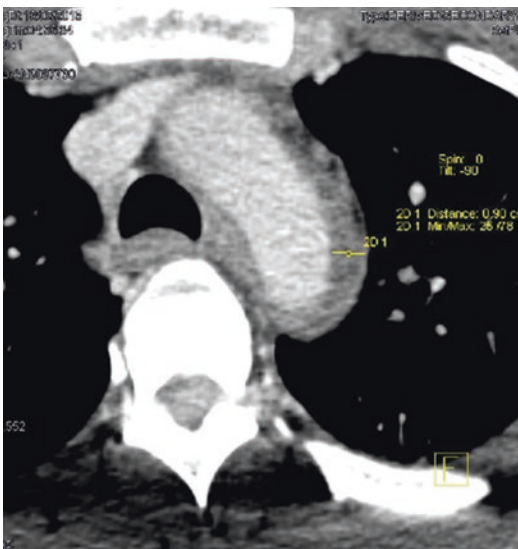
Axial CT scan shows periaortic hematoma (obliterating the periaortic fat plane)
